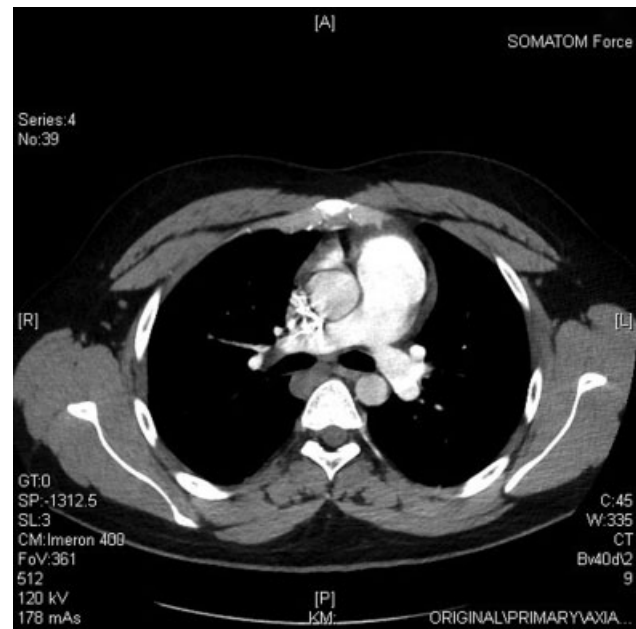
Computed tomography angiography of the chest: regressive thrombotic mass after 48 hours of heparin/alteplase.
